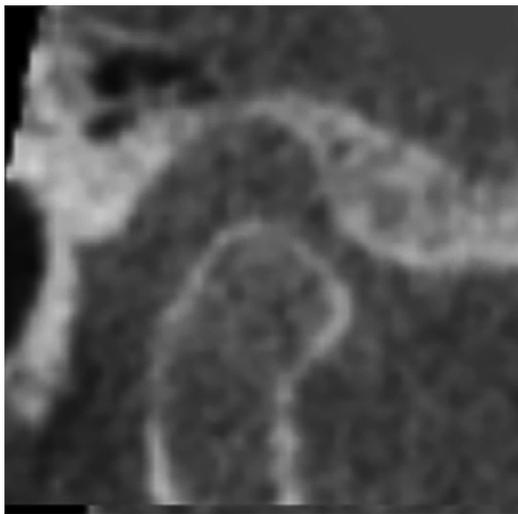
CBCT sagittal cross section shows flattening of the articular surface of the condyle, suggestive of functional remodeling. This is an attempt by the bone to increase the surface area to dissipate the increased loading on the articular surface.
